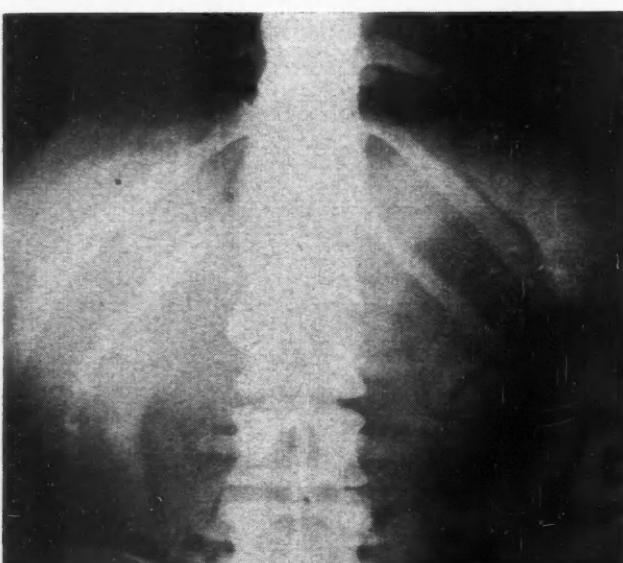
Radiograph of the upper abdomen 11 years after intracarotid injection of 30 c.c. of thorotrust. Note the homogeneous quality of the liver shadow, the nodular appearance of the spleen shadow and the radio-opaque lymph nodes in the celiac region.
